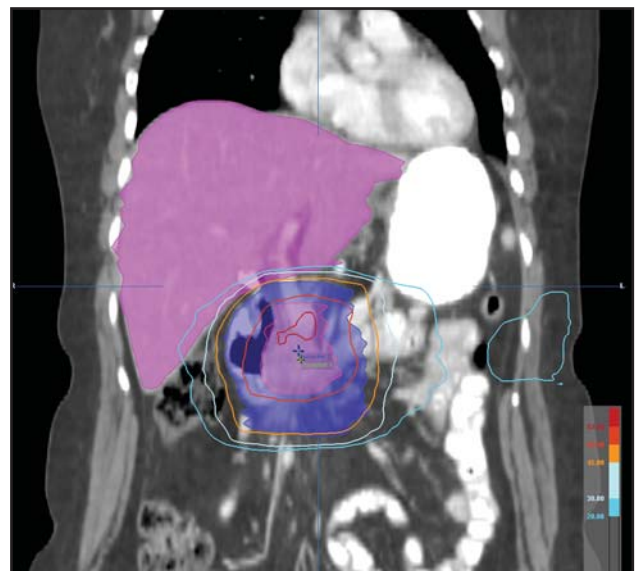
Coronal image displaying the treatment plan delivering 45 Gy in 25 fractions to the clinical target volume followed by a 5.4-Gy boost to the gross target volume. Note that the surrounding bowel is in the low-dose region. The C-loop of the duodenum is within the clinical target volume. This case was planned using 4-D CT to individualize the margin needed to account for respiratory motion. Treatment was delivered on the Novalis unit with daily image guidance using the spine to verify the treatment position.
